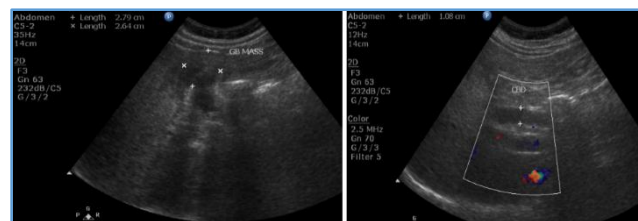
Abdominal Ultrasonography showing the Gallbladder Mass
